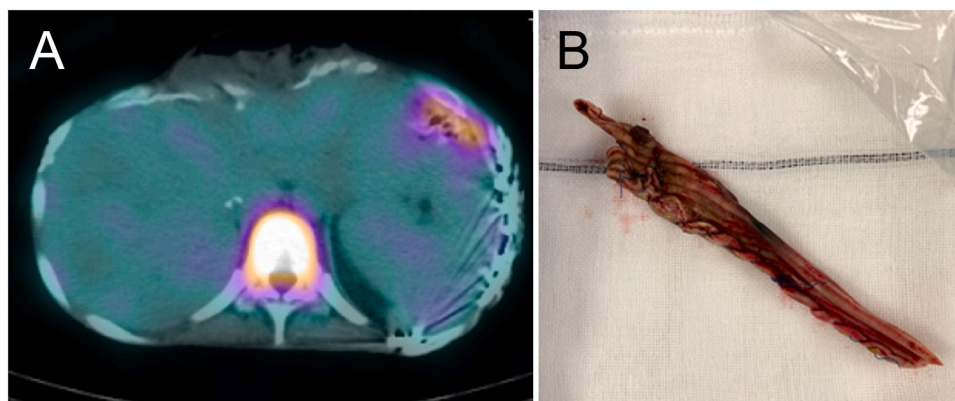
(A) Ga-67 scintigraphy showing accumulation in the soft tissue under the left diaphragm. (B) Residual component found in the abdominal cavity removed during the surgery.
